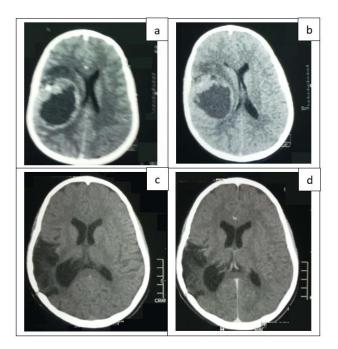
Pre- and post-operative CT scan. Preoperative parenchymal window CT without (a) and with contrast injection (b) showing a voluminous right parietotemporal mixed (cystic and fleshy) extra ventricular intraparenchymal, taking contrast at the level of the fleshy portion, well limited mass with perilesional edema, a mass effect on lateral ventricles and medial line deviation. CT images at 5 months postoperative parenchymal window without (c) and with contrast injection (d) showing right sequellar parietotemporal porencephalic cavity without tumor recurrence signs.
